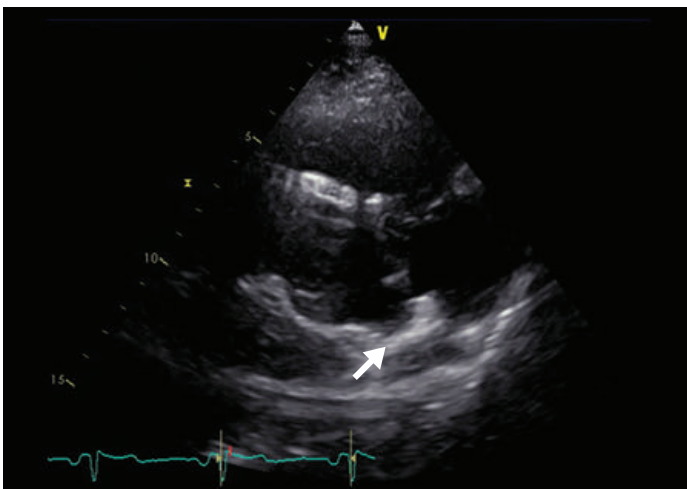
4 Echocardiographic image (modified parasternal long-axis view) of the right ventricle from a patient with ARVC/D diagnosed according to the revised Task Force Criteria.⁴ The right ventricle is dilated, and a large aneurysm (arrow) is detectable in the subtricuspid area. The reverberating structure in the center of the right ventricle is an ICD electrode.
